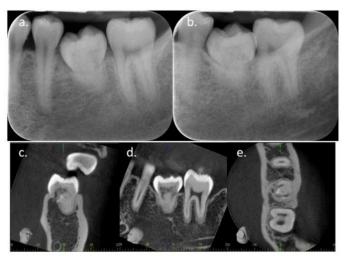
Straight on (a.) and horizontal tube shift (b.) periapical radiographs of tooth 28 (left maxillary third molar) transplanted to 36 (left mandibular first molar) area at 9 years follow-up showed pulp obliteration with diffused radiolucent area in the crown. CBCT images (coronal (c.), sagittal (d.) and axial (e.)) exhibited an ECR in the reparative phase²²
